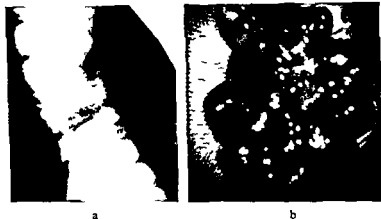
a) Polyp in the colon descends with apparent smooth surface at radiography b) Same polyp depicted through the colonoscope after endoscopic polypectomy Very irregular surface
